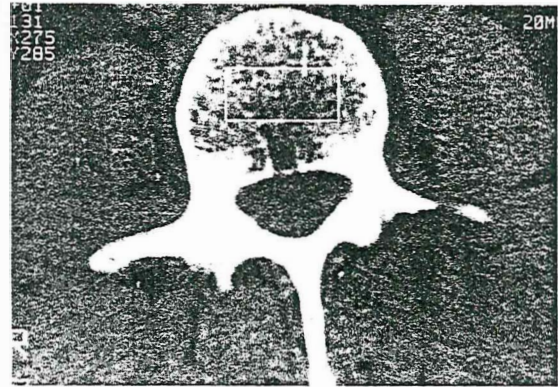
Preoperative CT of level L3-L4
